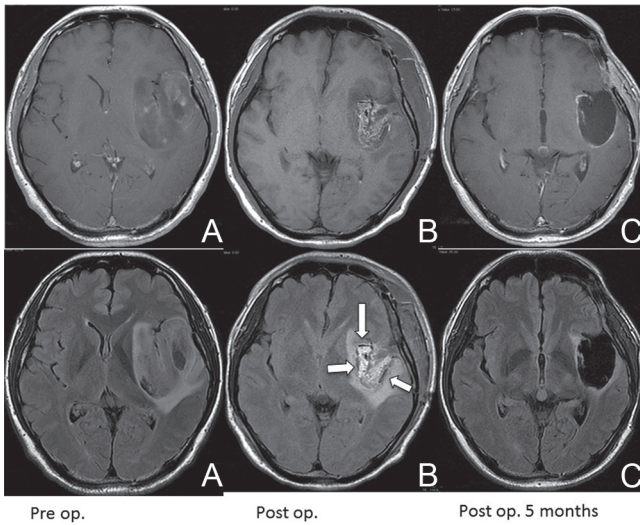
Axial gadolinium-enhanced T₁-weighted (upper row) and fluid-attenuated inversion recovery (lower row) magnetic resonance (MR) images. A: Preoperative MR images showing a mild enhanced tumor with perifocal edema in the left temporal lobe and insula. B: Postoperative MR images depicting the implanted carmustine wafers (arrows) on the surface of the resection cavity. C: MR images obtained 5 months after the operation demonstrating no tumor recurrence. The edema surrounding the cavity had improved. The presence of carmustine wafers was not confirmed.
